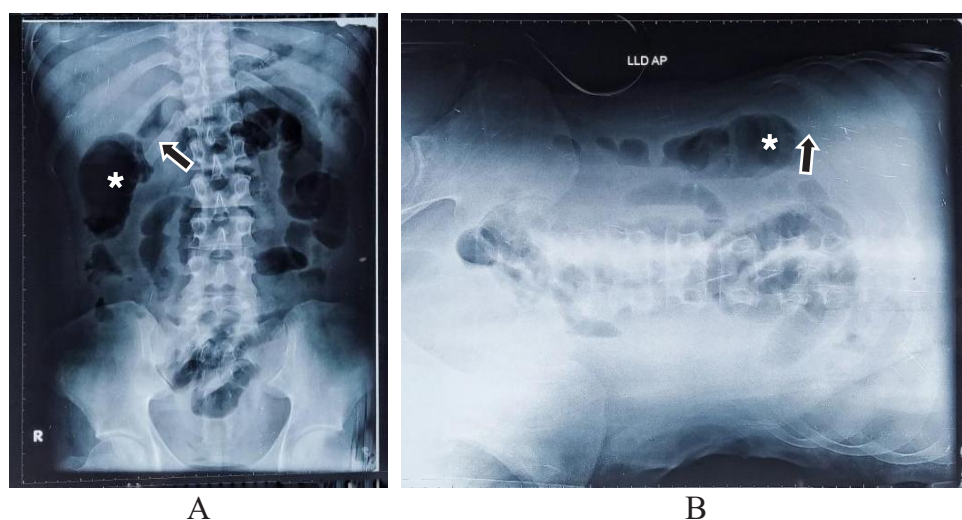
Abdominal X-ray in Erect position (A) and left lateral decubitus (LLD) position; (B) revealed a narrowing of the lumen of ascending colon that does not change upon different positions (arrow). Gas and fecal material were partially obstructed (asterisk).
